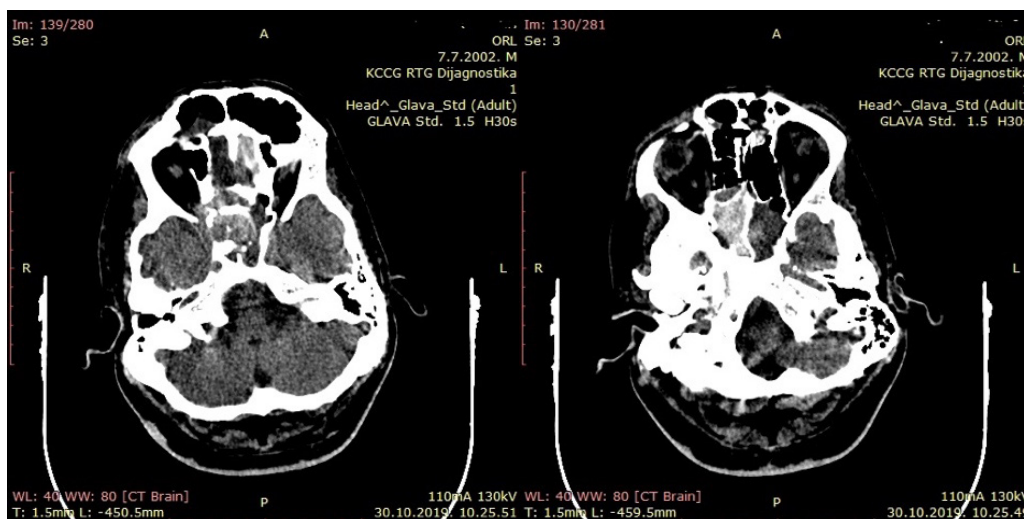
Initial CT scan show fracture of the scall base and bleeding in the maxillary sinus
